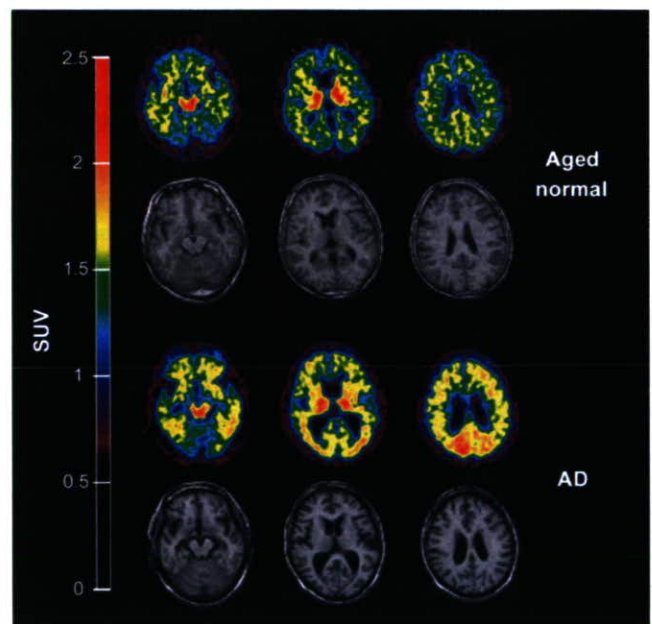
Mean SUV images between 20 and 40 min after injection of ^{11}C -BF-227 in aged normal subject (top, 70-y-old woman) and AD patient (bottom, 68-y-old woman). Coregistered MR images are shown below PET images.
